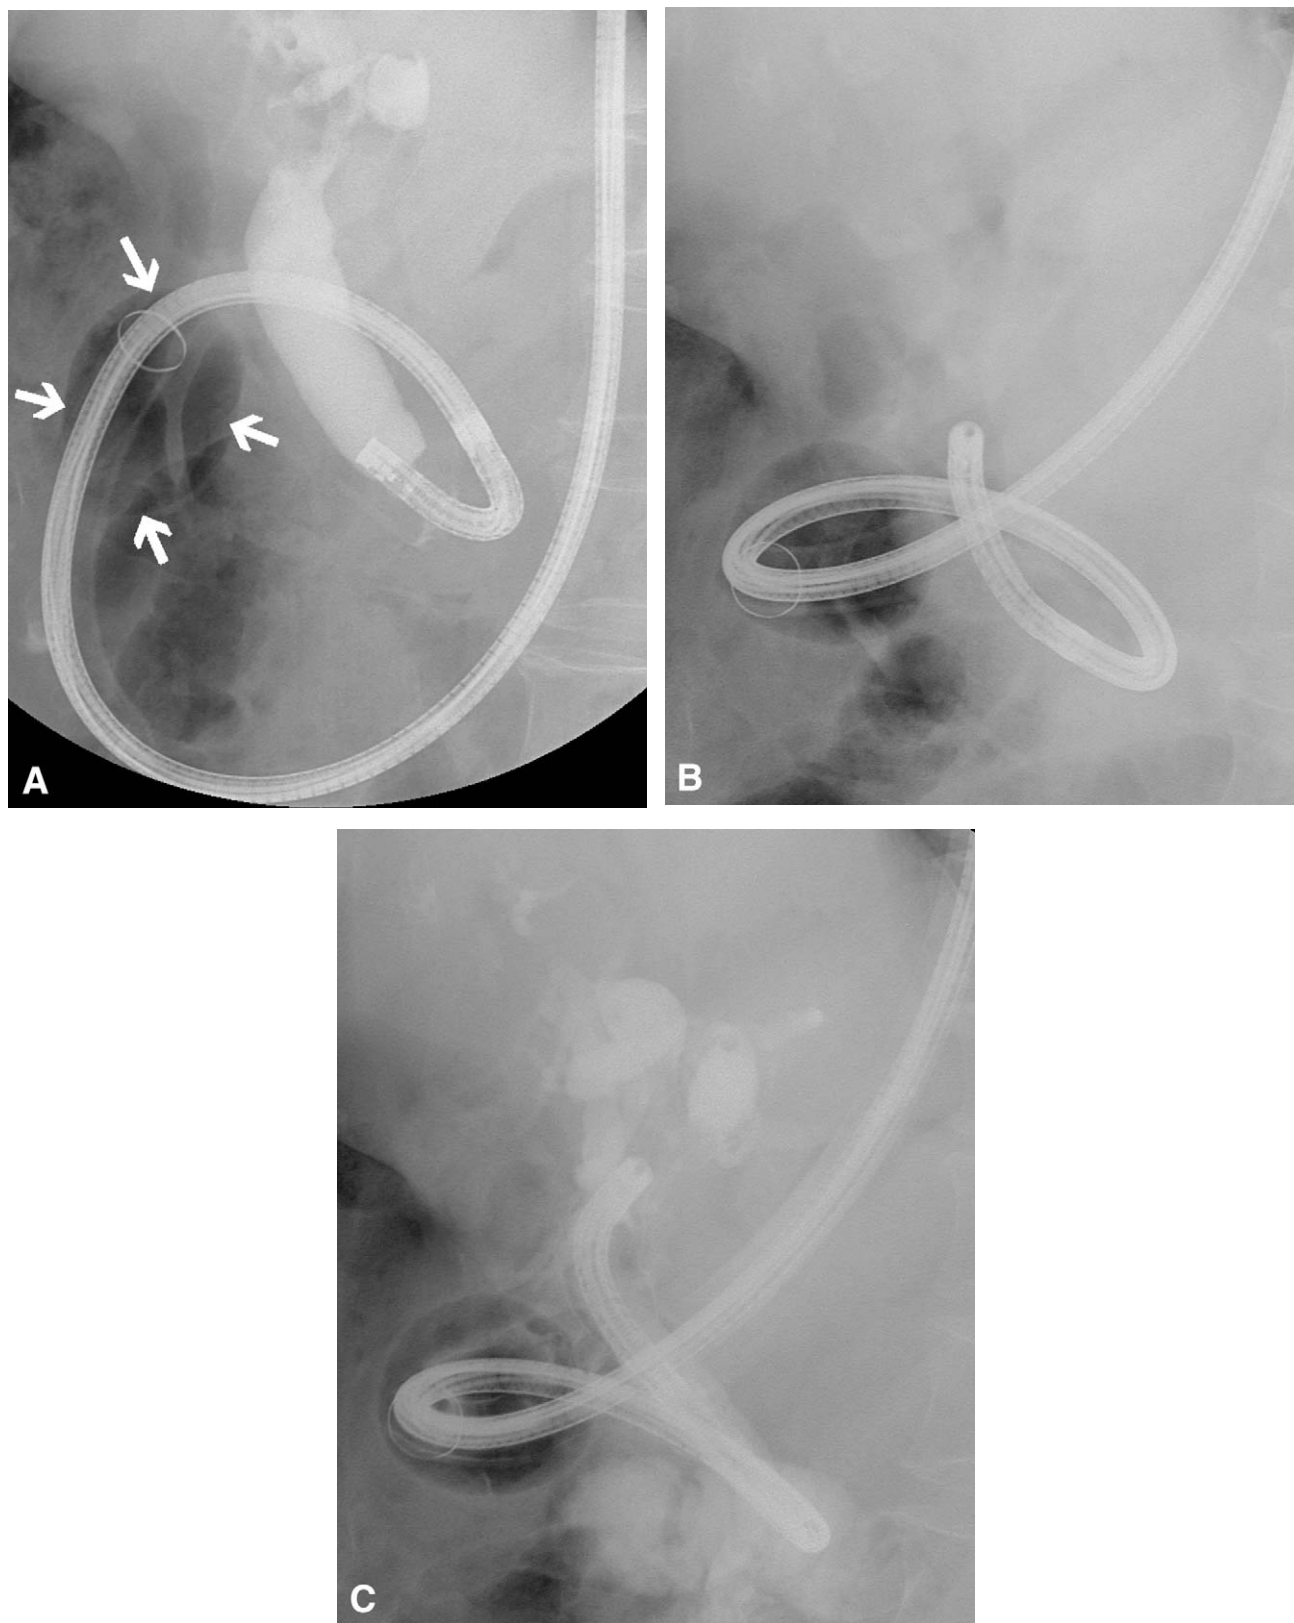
Radiographs, showing an ultra-slim upper endoscope advancing into the bile duct through the overtube (*arrow* indicates the balloon of the overtube). A, The endoscope was advanced into the ampullary portion. B, The endoscope was advanced into the distal CBD. C, The endoscope was advanced into the bifurcation.
